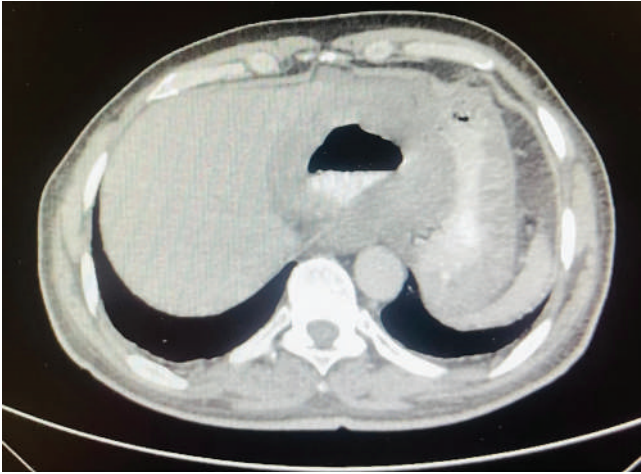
Giant esophageal diverticulum CT scan image.
